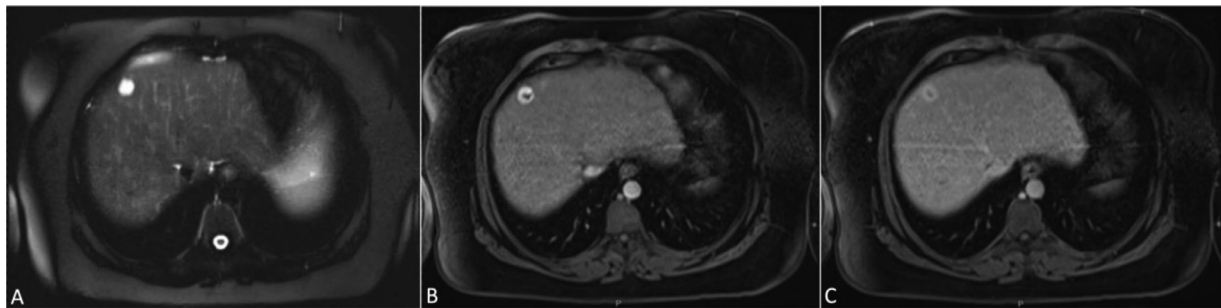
MRI performed 18 months later demonstrating interval growth and (A) T2 fat-suppressed imaging demonstrating more heterogeneous T2 signal (B) late arterial phase postcontrast imaging showing rim like pattern of enhancement and (C) equilibrium phase imaging demonstrating persistent rim like pattern of enhancement.
